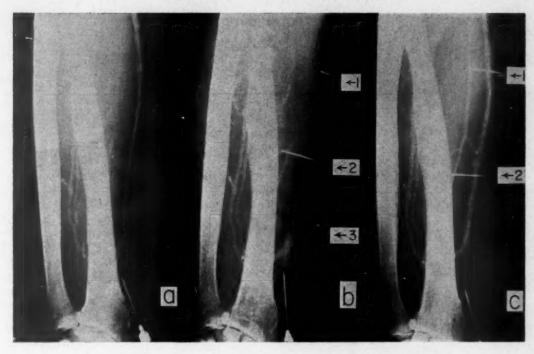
Case 2. Roentgenographic demonstration of clot lysis; (a) prior to induction of the clot; (b) immediately prior to the SK infusion; 20 cm. clot induced forty-eight hours previously; (c) eighteen hours after SK infusion demonstrating that persistent clot lysis has occurred. Radiopaque lines (1) and (2) define original area of clot induction; arrow at (3) indicates detail portion of clot.
